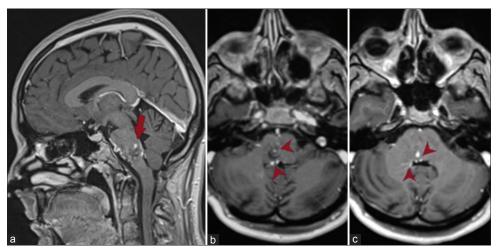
(a-c) Postoperative magnetic resonance imaging T1-weighted sagittal (a) and axial (b and c) images with gadolinium show residual gliotic hemosiderin tissue (arrow) around the small veins – tributaries of the developmental venous anomaly (arrowheads)
